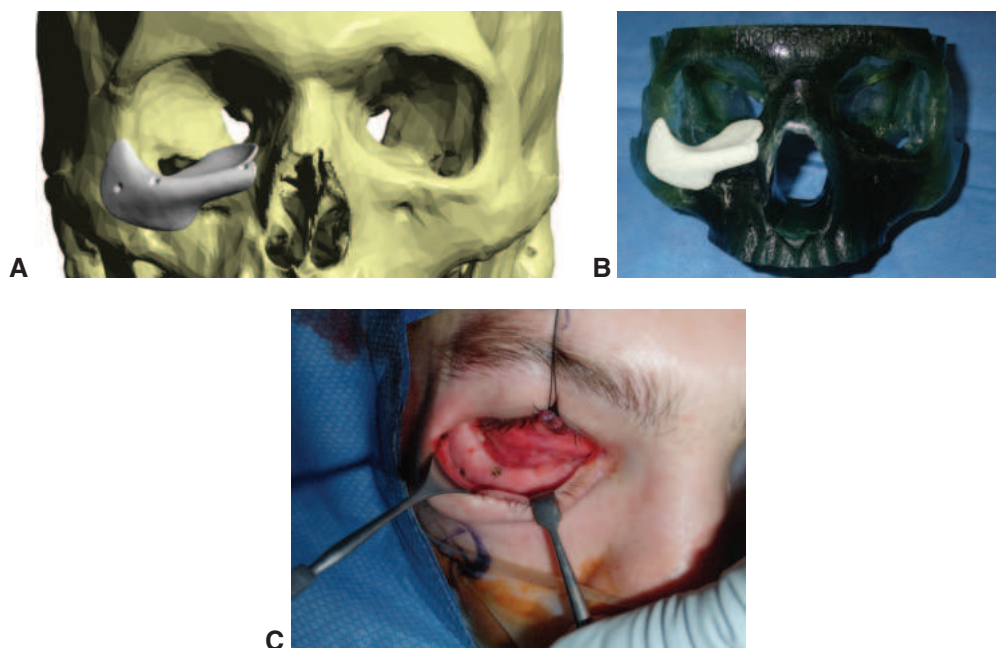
Patient-specific, customized orbital implants. Custom orbital implants made from CT measurements of contralateral orbital anatomy may benefit patients, especially those with complex trauma or who require revision surgery. A, CT modeling with 3D rendering of the customized orbital implant. B, Placement of customized orbital implant on 3D-printed skull. C, Intraoperative placement of orbital implant. (Courtesy of Steven M. Couch, MD.)
